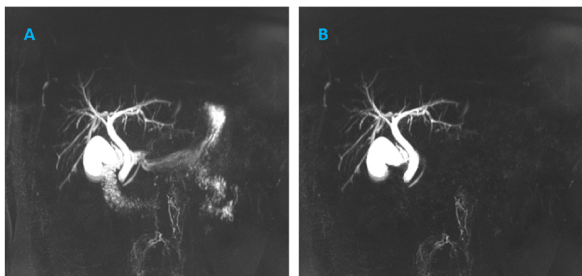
MRCP longitudinal slice of the abdomen (T2-weighted) during imaging circumstances: fast-recovery fast spin-echo transverse oblique 3D respiratory triggered. (A)pre-contrast (B) post-contrast.
